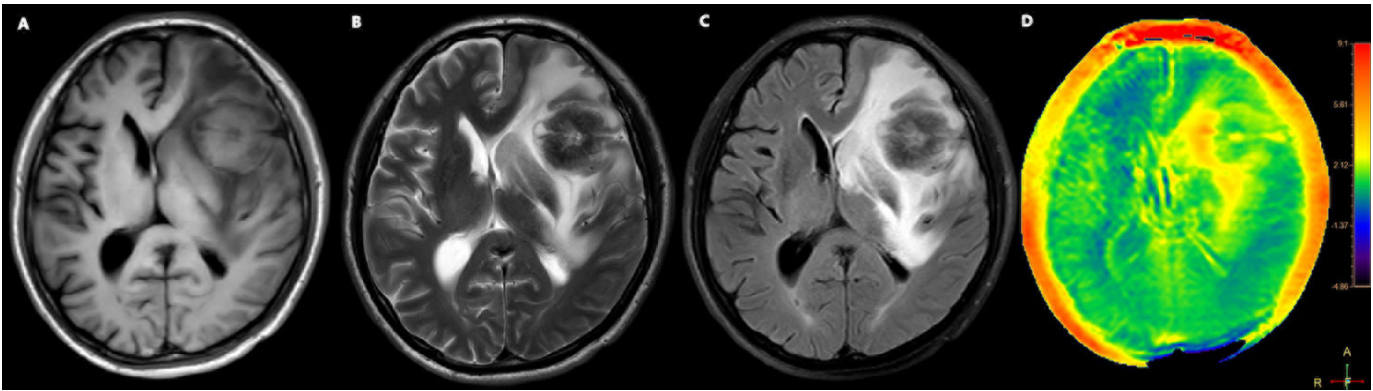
A 55-year-old male with glioblastoma. The tumor was located in the left frontal lobe, demonstrating a slightly hypointense signal on T1WI (A), and a heterogeneously isointense to hyperintense signal on both T2WI (B) and T2-FLAIR (C) sequences with cystic components. The APTw image (D) shows a heterogeneously hyperintense mass.
